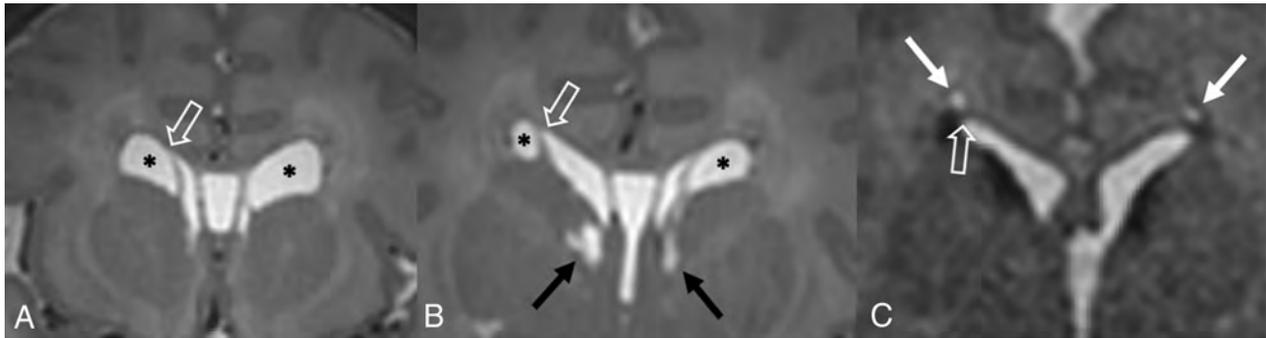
Periventricular cysts. A, Coronal T2-weighted MR image from a 1-week-old girl with a history of germinal matrix hemorrhage demonstrating coarctation of the bilateral frontal horns with connatal cyst formation (*asterisks*). Note that these cysts are at the level of the superolateral angles of the lateral ventricle (*open arrow*). B, Coronal T2-weighted MR image from the same patient demonstrating subependymal cysts (*black arrows*) located near the caudothalamic groove below the level of the superolateral angles (*open arrow*). Additional connatal cysts are present (*asterisks*). C, Coronal T2-weighted MR image from a 1-month-old boy with a history of germinal matrix hemorrhage and peripartum hypoxia demonstrating small bilateral periventricular cysts (*white arrows*) located above the level of the superolateral angles (*open arrow*). This appearance is consistent with cystic periventricular leukomalacia.
